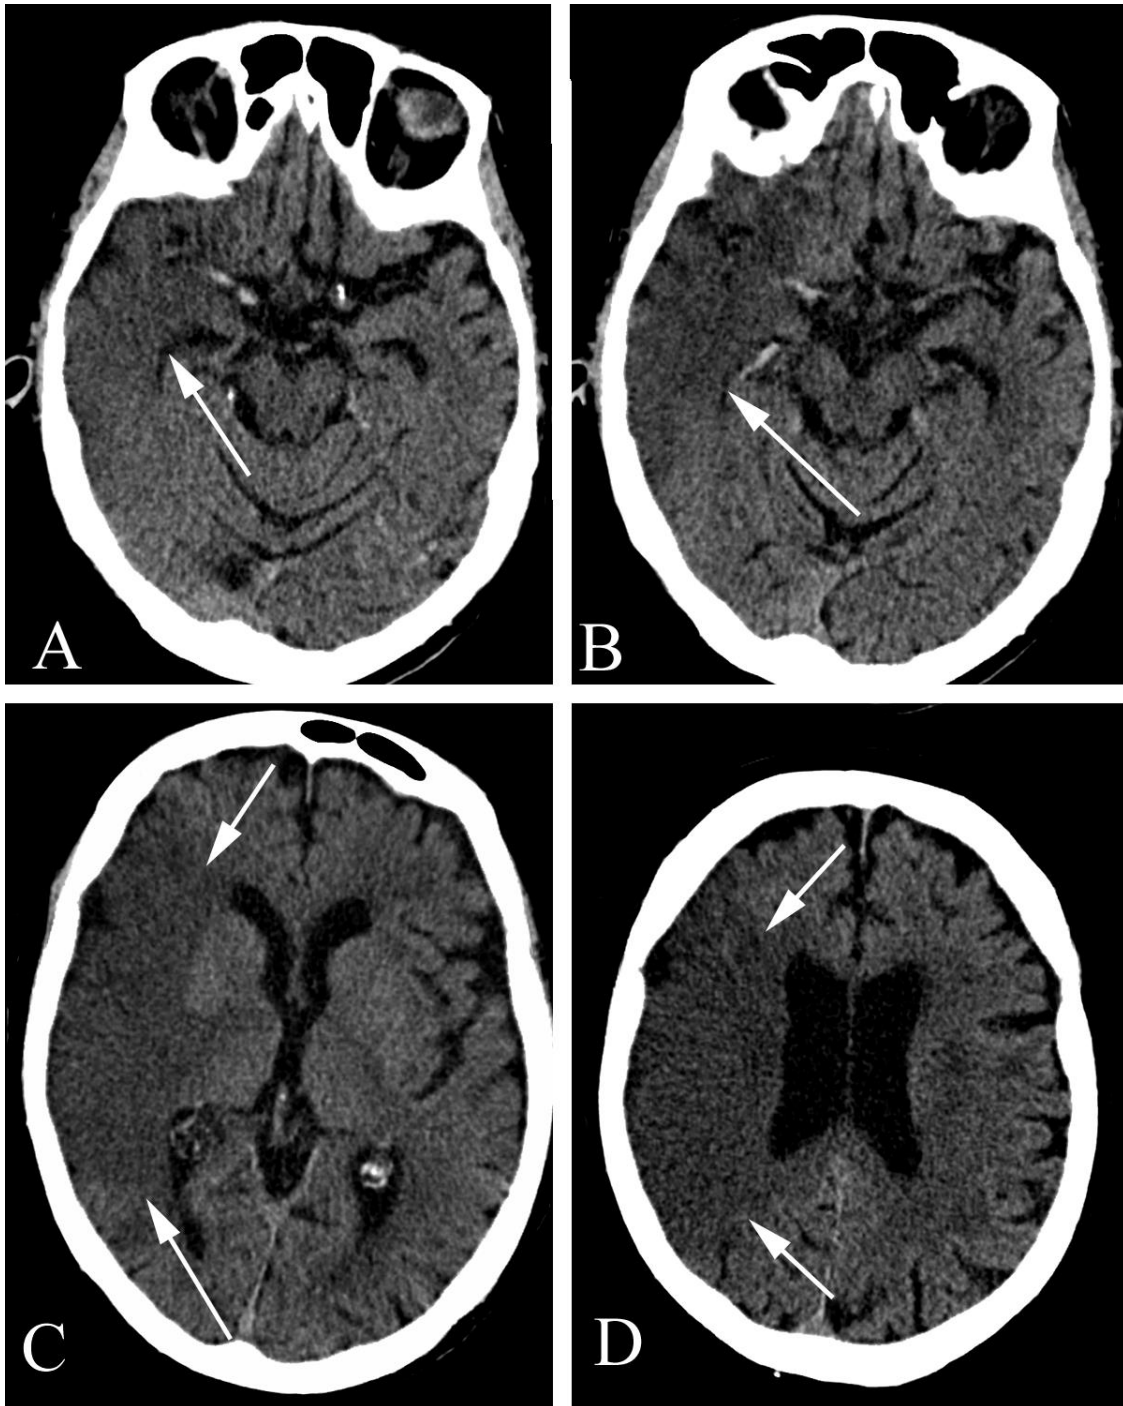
Huge acute cerebral stroke in an 88 year old woman who woke with left hemiparesis. A. Unenhanced axial CT at the level of the suprasellar cistern demonstrates hypodensity and effaced sulci in the right temporal lobe (arrow). Note the calcified vascular tree. B. Unenhanced axial CT superior to A. also demonstrates hypodensity and effaced sulci (arrow). C. Unenhanced axial CT at the level of the basal ganglia demonstrates a large area of the right cerebral hemisphere (basically the entire distribution of the right middle cerebral artery) with effaced sulci and hypodensity (arrows). D. Unenhanced axial CT through the mid lateral ventricles shows extension of the large, acute infarct through the cerebral convexity. Such a large acute stroke, involving more than 33% of the hemisphere, contraindicates fibrinolytic therapy for stroke.
